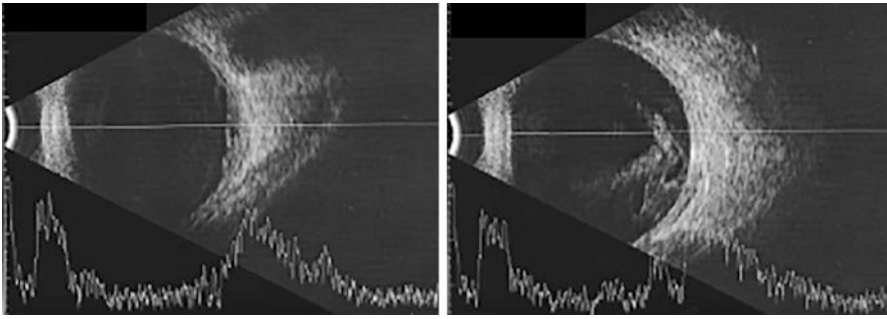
Ultrasound B-scan images of a 44-year-old male patient, who presented with primary vitreal lymphoma following renal transplant, show moderately echogenic vitreous opacities with exudative retinal detachment
